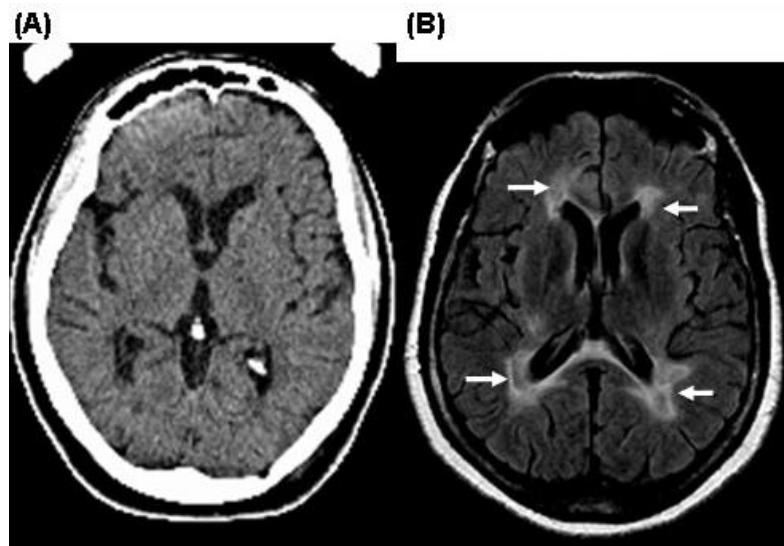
(A) CT scan and (B) MRI showing the increased sensitivity that MRI adds in visualizing brain lesions, such as those in MS (arrows).
